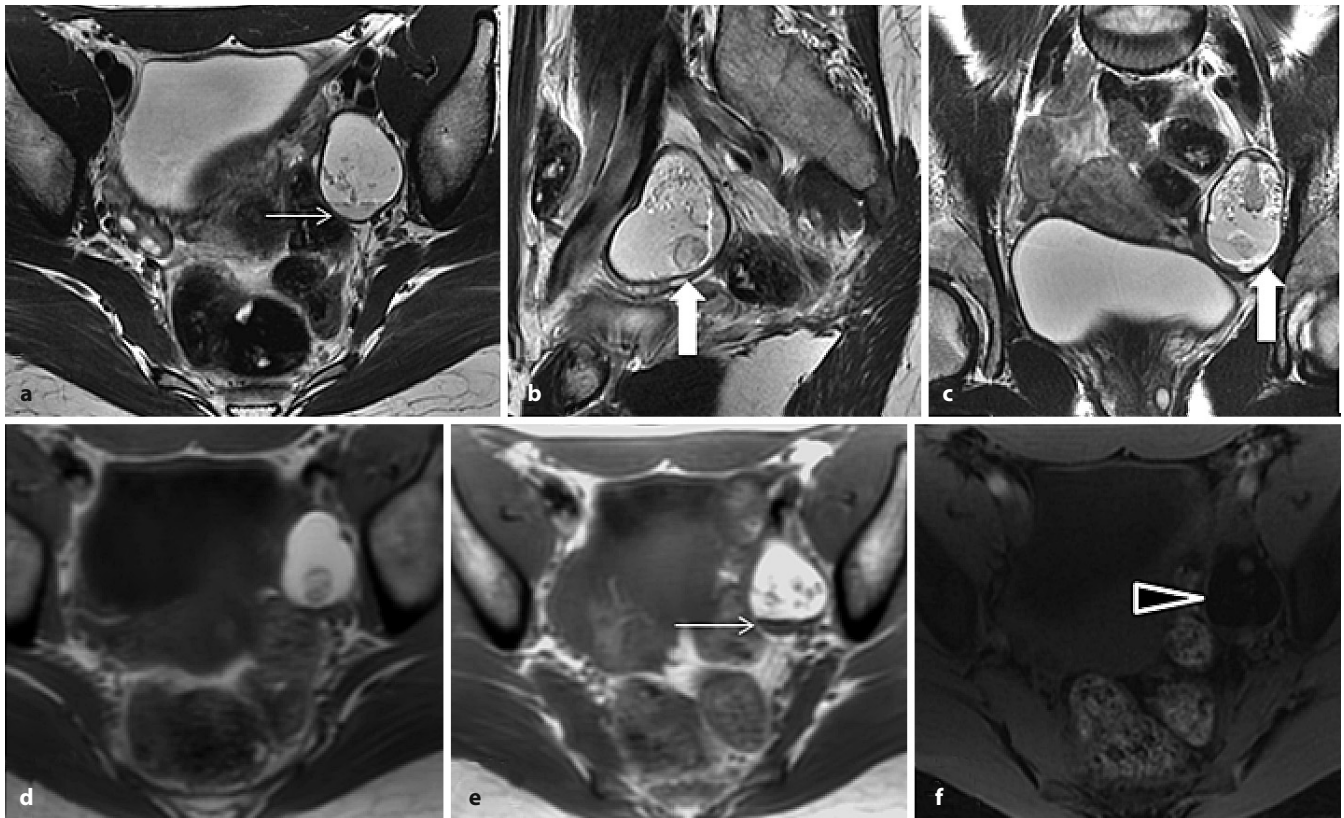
a-f. Mature ovarian cystic teratoma. a Axial, b sagittal, and c coronal fast-spin-echo T2-weighted images (FSE T2-WI) show high T2-signal-intensity unilocular left cystic ovarian lesion, with hypointense mural protrusions (i.e., dermoid plug; *large arrow* in b and c). d, e On axial T1-WI, lesion demonstrates high signal intensity characterized signal drop on f fat-saturated (FS) T1-WI (*arrowhead*) due to lipid content, with evidence of fluid-lipid level (*thin arrow* in a and e)
